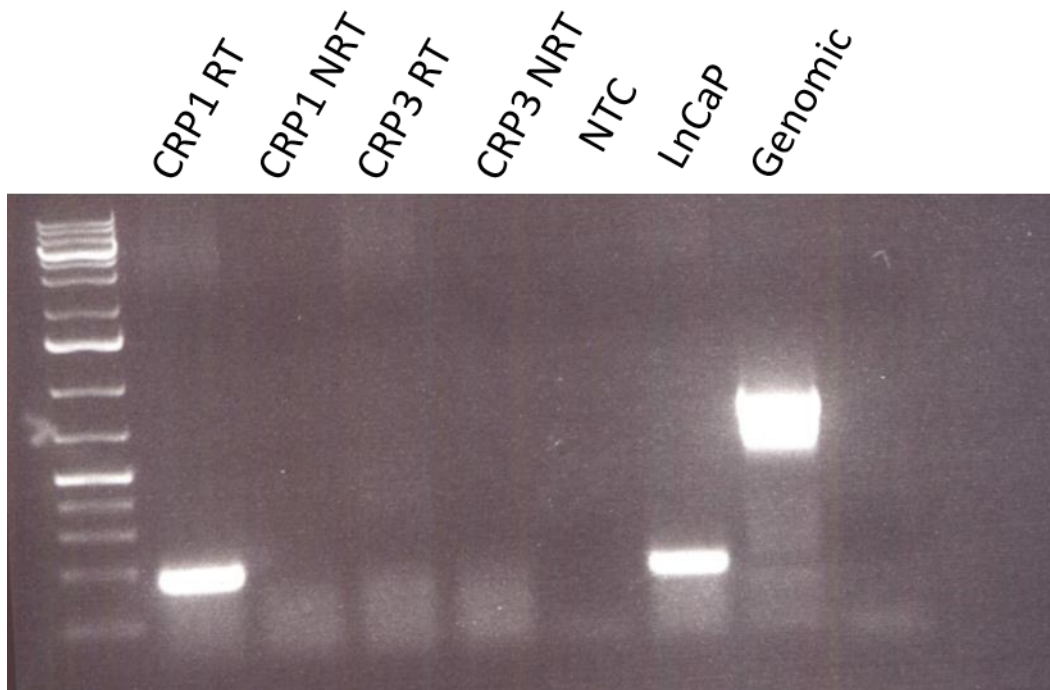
RT-PCR showing robust PSMA mRNA expression in CRP-1 prostate sample, CRP-3 prostate sample was used as negative control and does not express PSMA in the prostate. RT and NRT refers to presence or absence of enzyme reverse transcriptase respectively. NTC refers to no template control.
